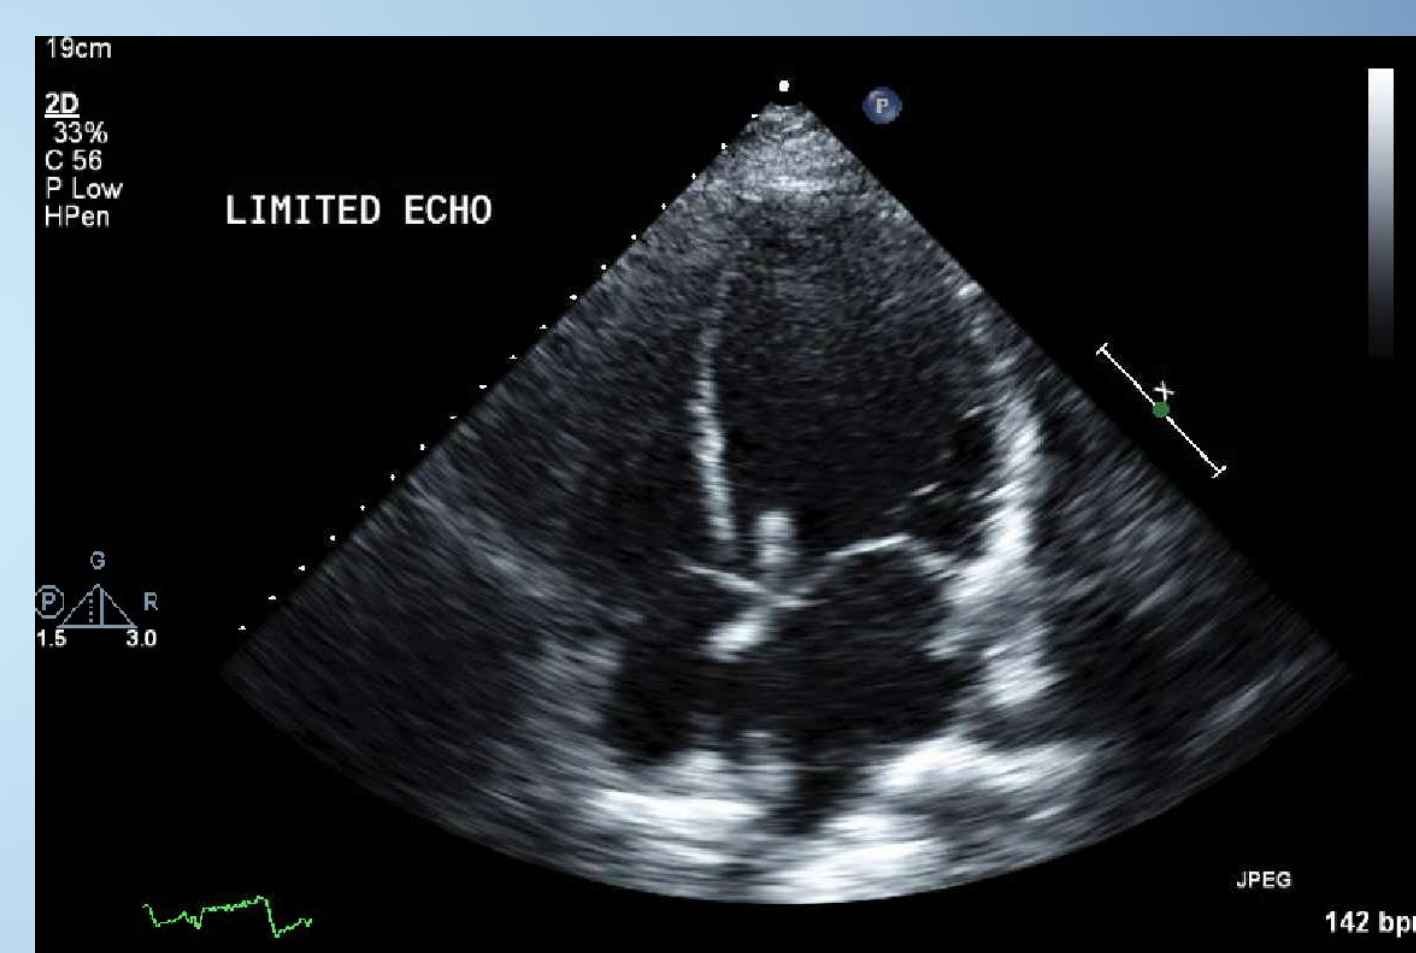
Pre-operative transthoracic echocardiogram. Left Ventricular End Diastolic Diameter was 6.6cm.
